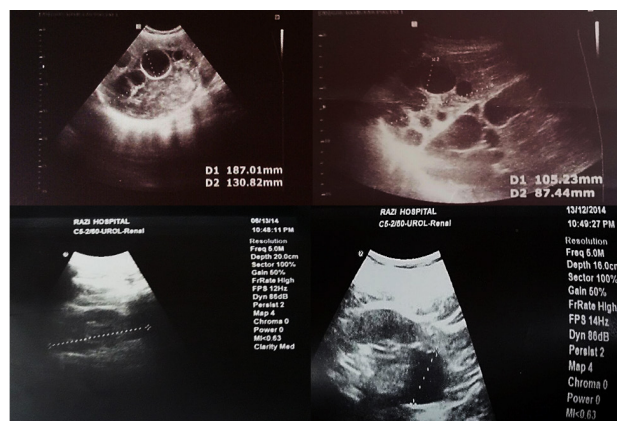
Ultrasound of the Liver and the Urinary System. In the above images multiple hydatid cysts are seen. In below images, a large hydatid cyst in the bladder neck of the patient's is visible.
